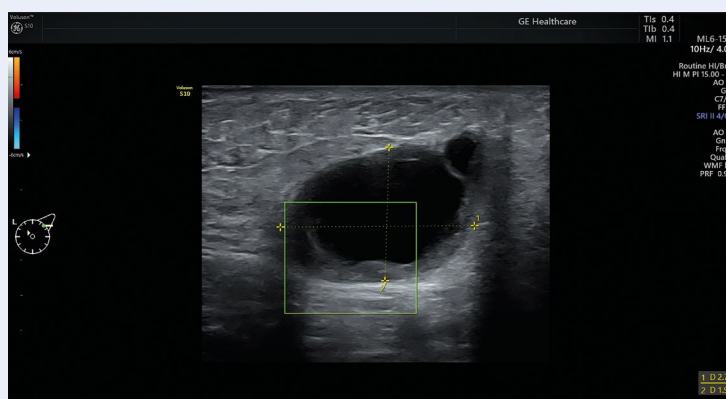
Ultrasound image of the left breast. A metastatic lymph node
